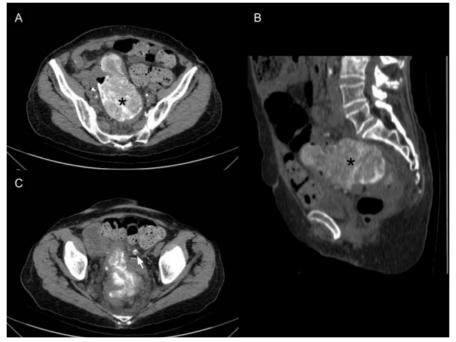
Unenhanced pelvic CT. A: Axial; B: sagittal planes showing a heterogeneous hyperdense expansile lesion (*) without cleavage plane with sigmoid colon and intraperitoneal rectum, and anatomically deforming them; C: Similarly hyperdense nodules (arrow) were also identified on the peritoneal surface of the pelvis.
